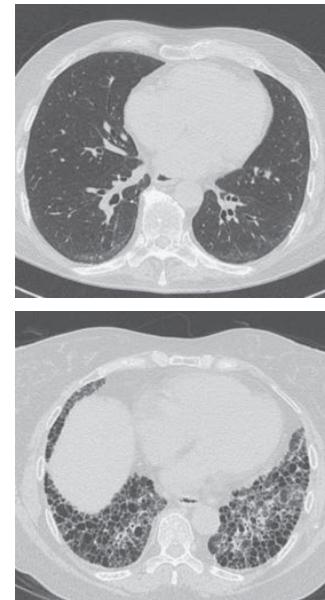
High-resolution chest CT findings in systemic sclerosis. Top panel: Early interstitial lung disease with subpleural reticular and ground-glass opacities in the lower lobes. Patient in supine position. Bottom panel: Extensive lung fibrosis with coarse reticular honeycombing and traction bronchiectasis. (Courtesy of Rishi Agrawal, Northwestern University.)
